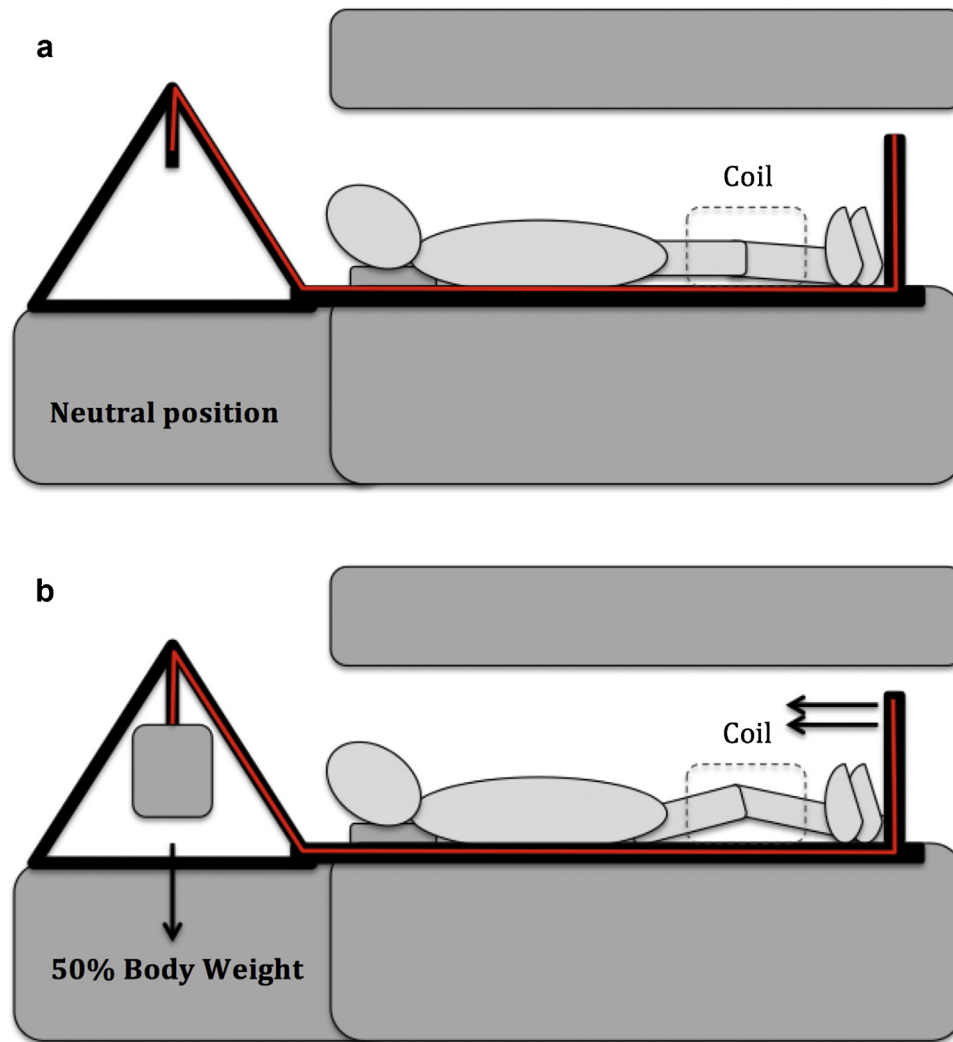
MRI-compatible axial loading device. (a) For unloaded imaging, the subject is in neutral position with the leg extended. (b) For loaded imaging, hanging weights equaling half of the patient's body weight are applied to the frame that. The force of the weight is transmitted through a series of pulleys to the patient's foot.
